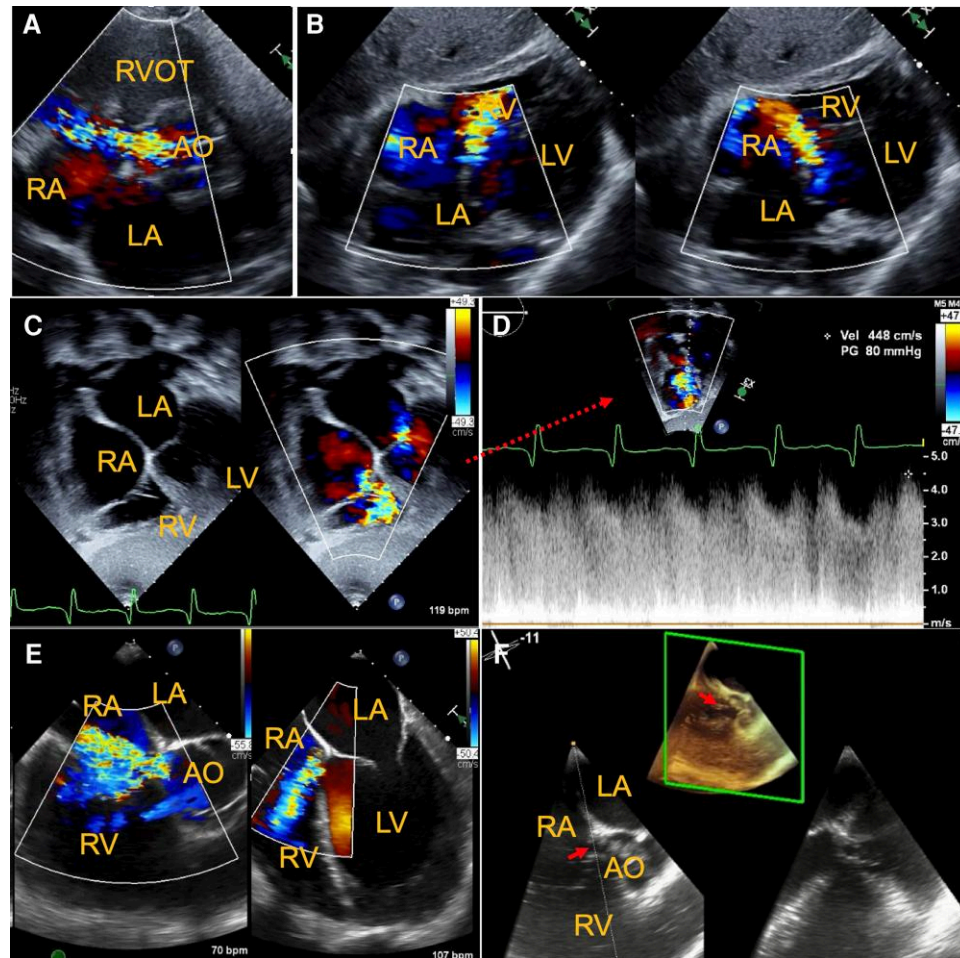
Echocardiographic images. TTE images in parasternal short axis view at aortic valve level (A) and subcostal four-chamber view (B) showed a left-to-right jet swaying in direction during cardiac cycle. Doppler study using paediatric probe in modified apical four-chamber view showed a biphasic high velocity left-to-right flow (C, D). Two-dimensional TEE midesophageal aortic valve short axis (E, left) and midesophageal four-chamber views (E, right), as well as three-dimensional TEE view of the aortic valves (F) showed non-coronary SOV rupture (red arrows) with a left-to-right flow swaying into RA and RV (E, F). RA, right atrium; RV, right ventricle; LA, left atrium; LV, left ventricle; AO, aorta; RVOT, RV outflow tract; SOV, sinus of Valsalva.
